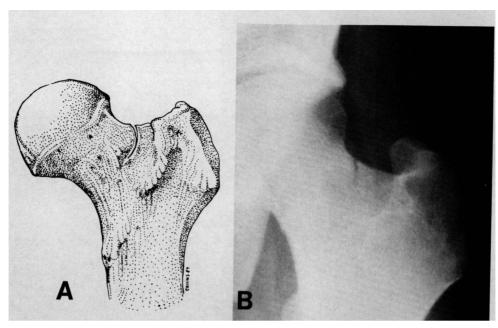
A, tension-side stress fracture with widening of the fracture line. B, radiograph of opening of tension-side femoral neck stress fracture.
